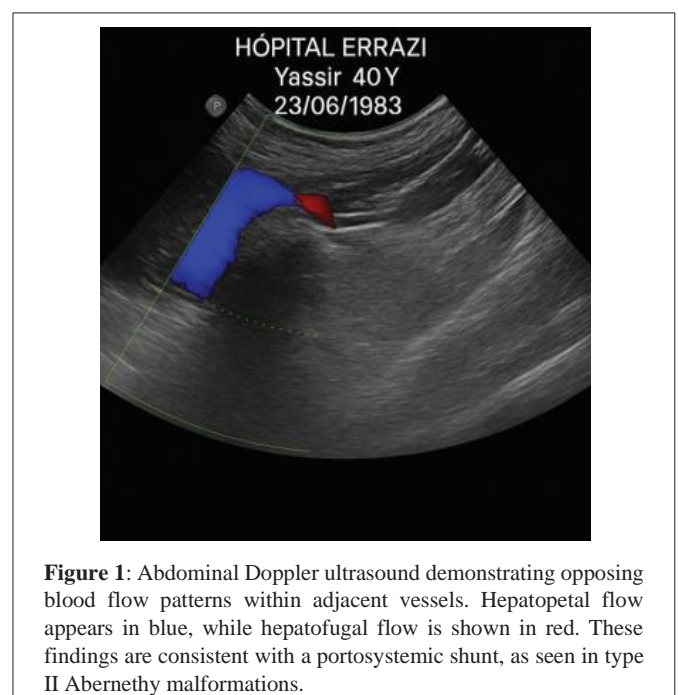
Abdominal Doppler ultrasound demonstrating opposing blood flow patterns within adjacent vessels. Hepatopetal flow appears in blue, while hepatofugal flow is shown in red. These findings are consistent with a portosystemic shunt, as seen in type II Abernethy malformations.
